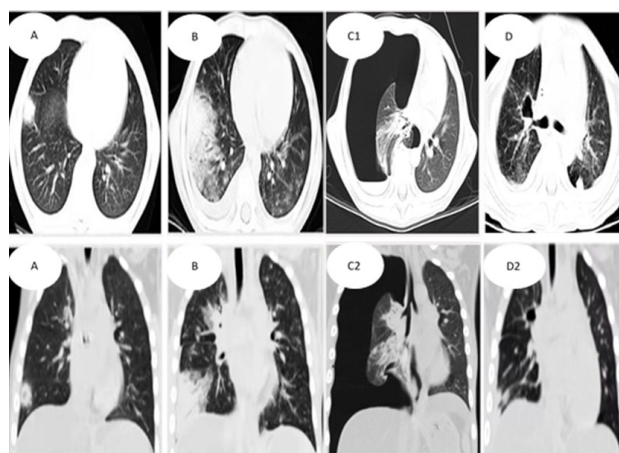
Pulmonary imaging. Chest CT showed exudation (A1 and A2); Chest CT showed that it was worse than before (B1 and B2); Chest CT showed massive pneumothorax with atelectasis and exudation on the right side (C1 and C2); Chest CT showed that the pneumothorax disappeared and the pleural effusion was absorbed (D1 and D2).
